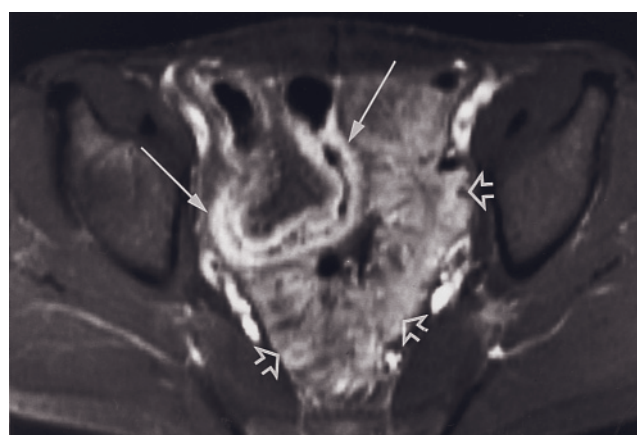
Ovarian carcinoma metastases to the peritoneal and serosal surfaces. Transverse 512-resolution T2-weighted echo-train spin-echo (*a*) and 90-s postgadolinium fat-suppressed SGE (*b*) images highlight the improvement in disease detection afforded by breath-hold gadolinium-enhanced fat-suppressed SGE. On the high-resolution T2-weighted image, bowel motion degrades image quality; no metastatic disease can be identified. On the gadolinium-enhanced fat-suppressed SGE image, the acquisition during suspended respiration avoids breathing artifact and minimizes bowel motion. Enhancement of irregularly thickened tissue along the peritoneum and serosal surface of bowel (arrows, *b*) is consistent with widespread metastatic disease.
